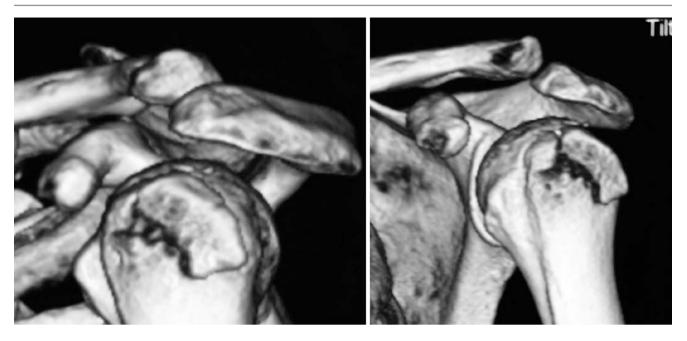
Three-dimensional CT reconstruction is helpful to evaluate the condition of bone fracture displacement
